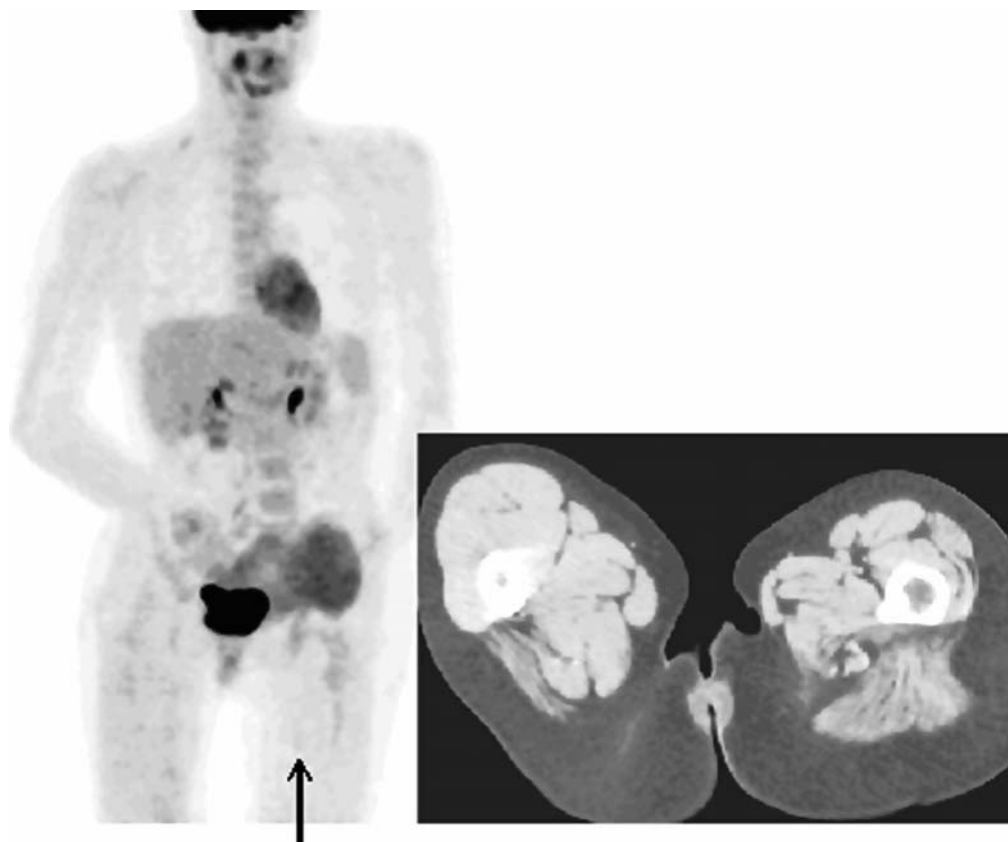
Left Panel: PET scan demonstrates large left pelvic sarcoma, with secondary edema of left leg (*arrow*), demonstrated in both PET image (*left panel*) and also in CT sections of thighs (*lower right panel*).
